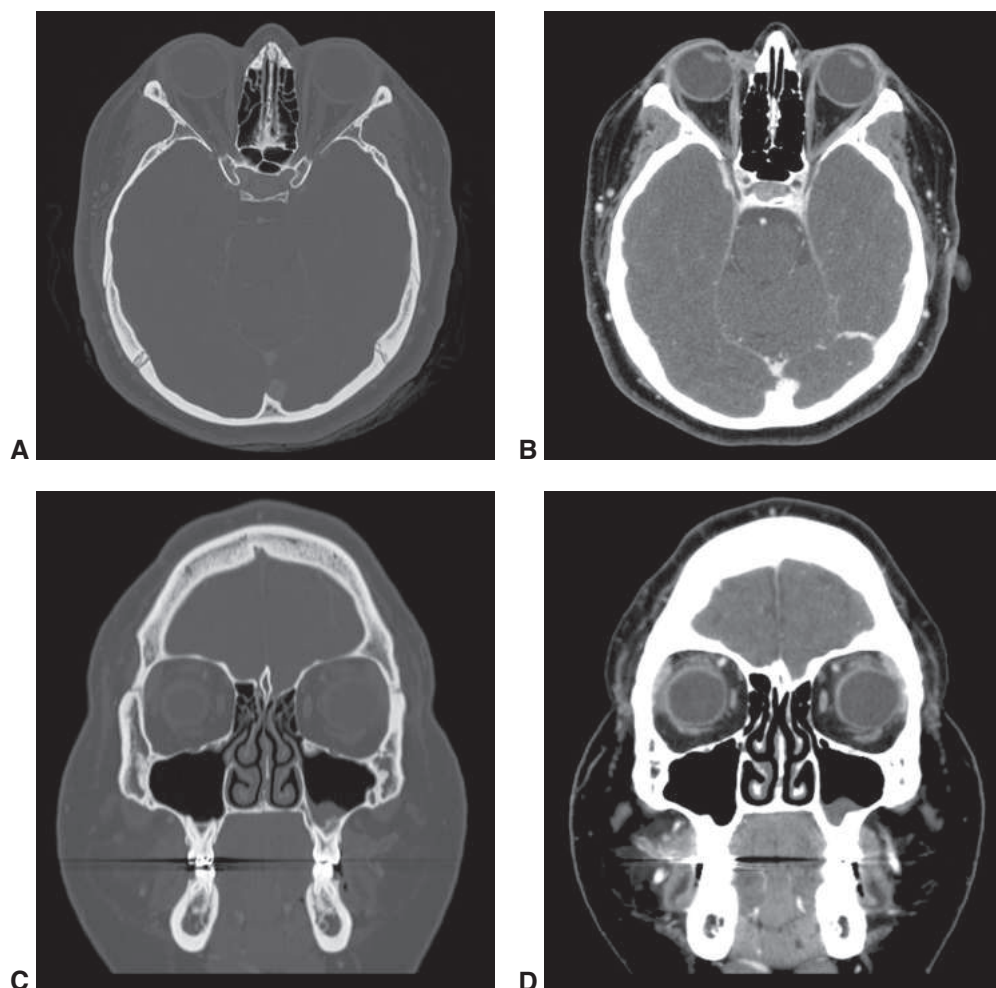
Computed tomography (CT) of the orbit, demonstrating normal anatomy. A, Axial view with bone window. B, Axial view with soft-tissue window. C, Coronal view with bone window. D, Coronal view with soft-tissue window. (Courtesy of Steven M. Couch, MD.)
